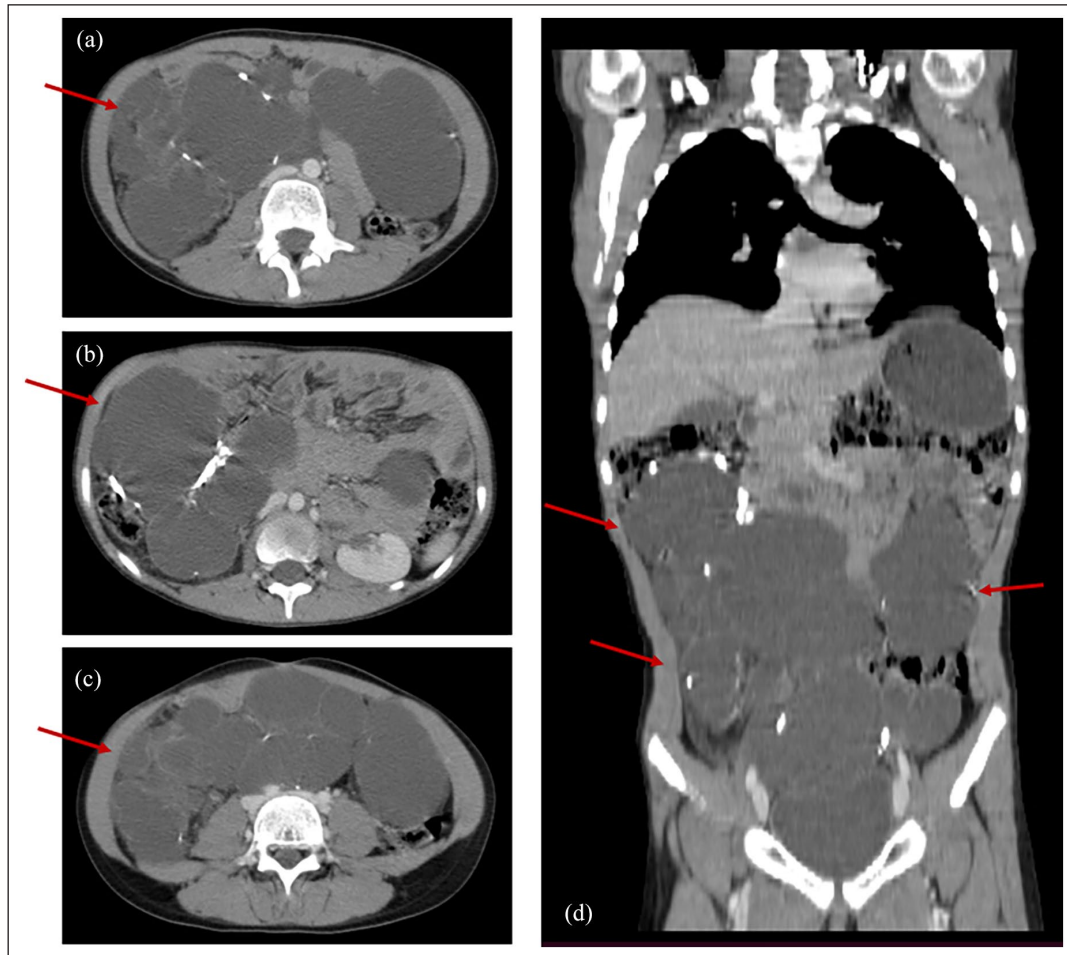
Computed tomography scan with contrast revealed a large multicavity cystic mass (see red arrows) involving most of the abdomen and extending into the right and left upper abdomen. (a)–(c) transversal view; (d) coronal view.
